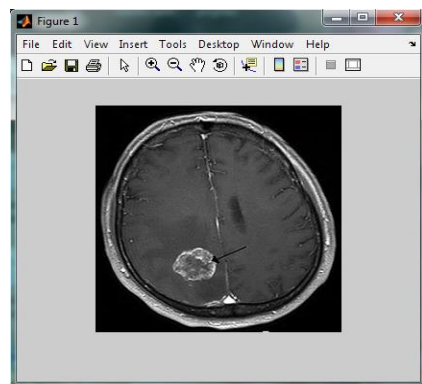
Input MRI Image
